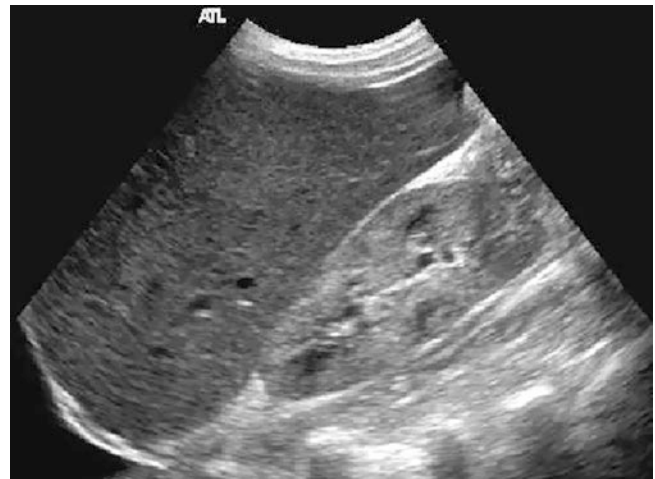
Ultrasound image of acute renal failure. Kidneys in acute failure can appear enlarged and diffusely hyperechoic, with loss of differentiation between the cortex and medulla. This appearance is often referred to sonographically as “medical renal disease.” (Image courtesy of Bret Nelson.)
